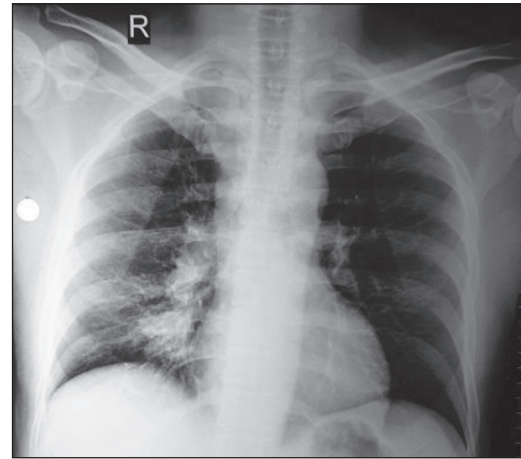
Chest radiograph demonstrates a right hilar mass
